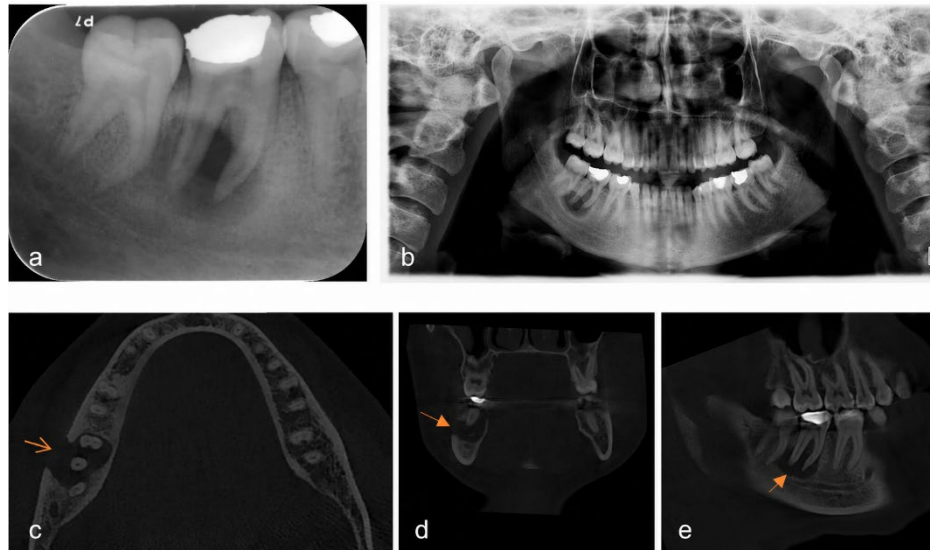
Radiographic and cone-beam computed tomography (CBCT) images of the periapical lesion and buccal cortical perforation associated with tooth #47. (a) Periapical radiograph, (b) panoramic radiograph, and (c–e) axial (c), coronal (d), and sagittal (e) CBCT sections. Arrows indicate the buccal cortical perforation.
